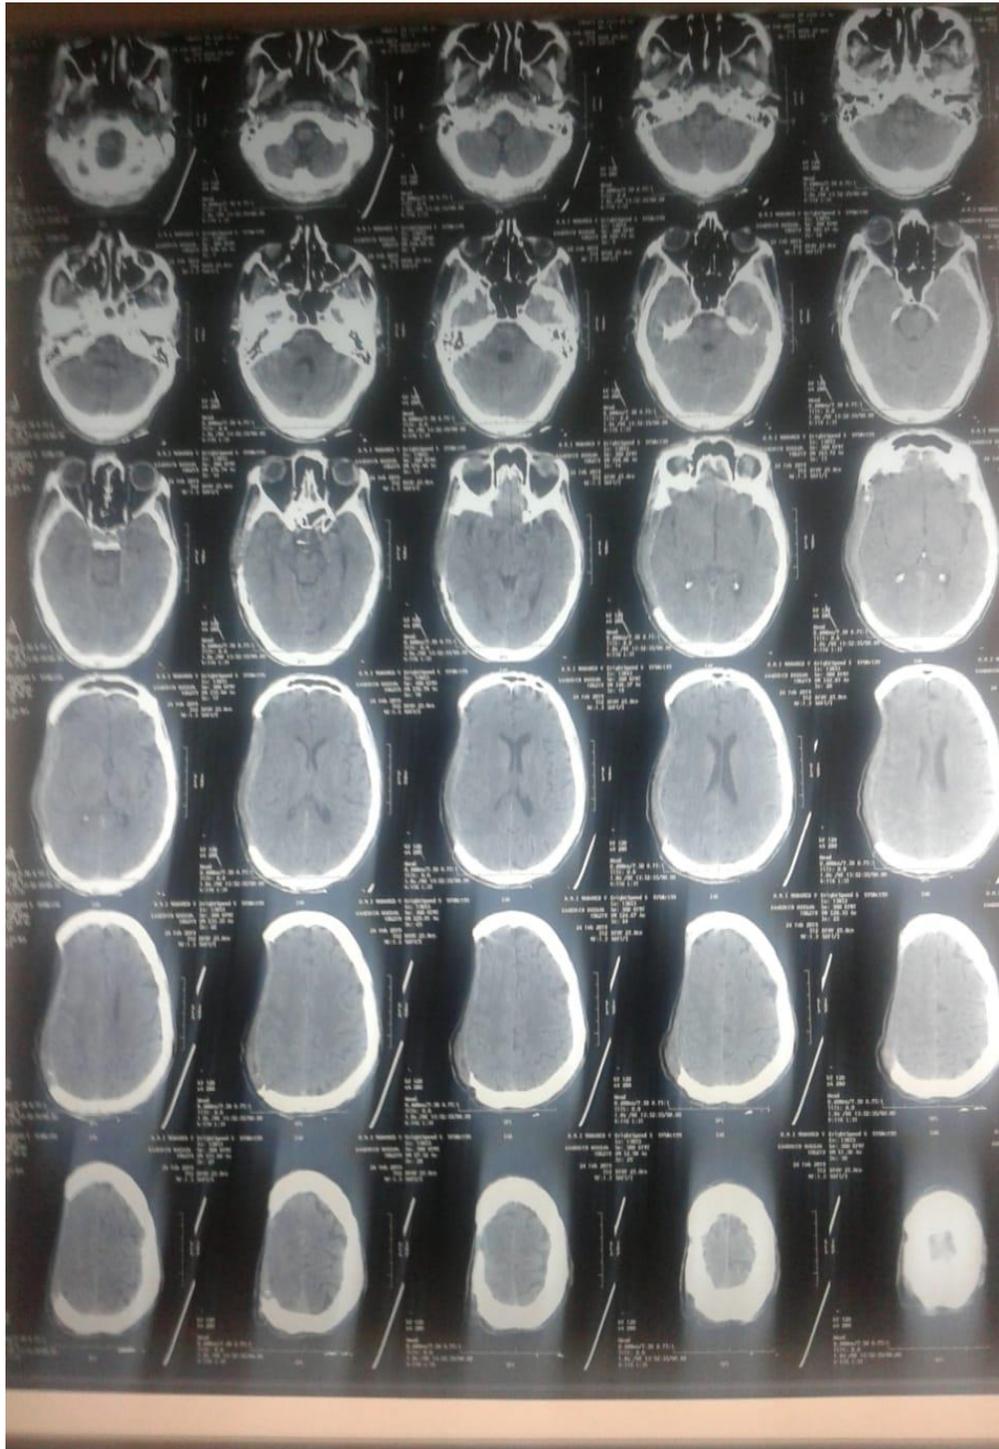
CT scan with Sinking Flap syndrome.
